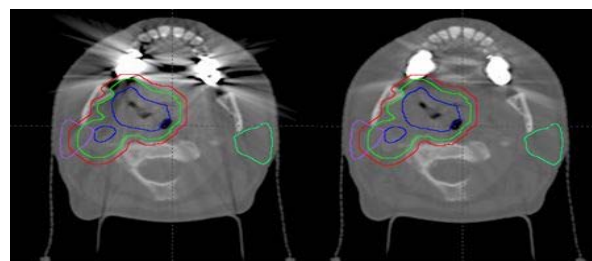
Planning-CT (left) and MAR-CT reconstruction (right) visualized with the contoured GTV (blue), CTV_{boost} (green) and PTV_{boost} (red), and both parotid glands (purple and lime).
